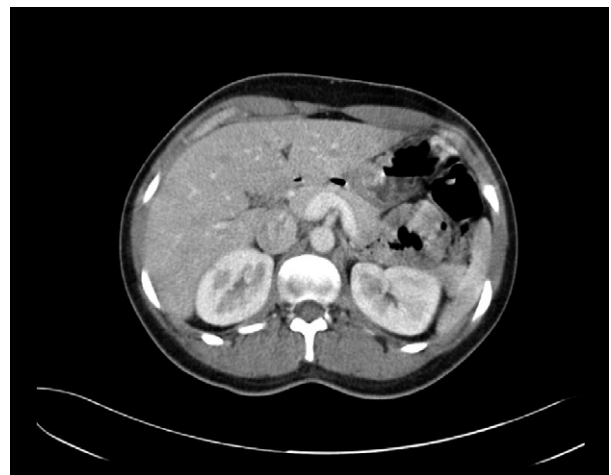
Computed tomography scan shows complete resolution of portal venous gas after hyperbaric oxygen therapy.
